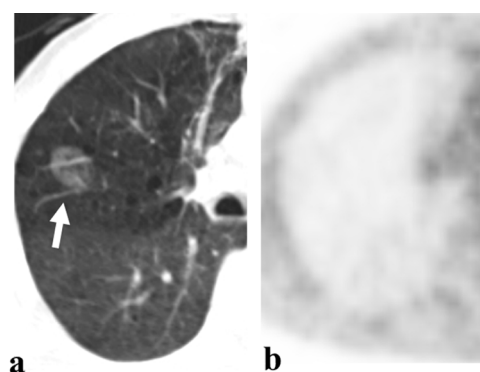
Axial ¹⁸F-FDG PET/CT images of a 54-year-old male with LPA. a) CT image (lung window) showing a 30-mm-sized pure ground glass nodule in the right lung (arrow). b) There is no ¹⁸F-FDG uptake in the nodule
